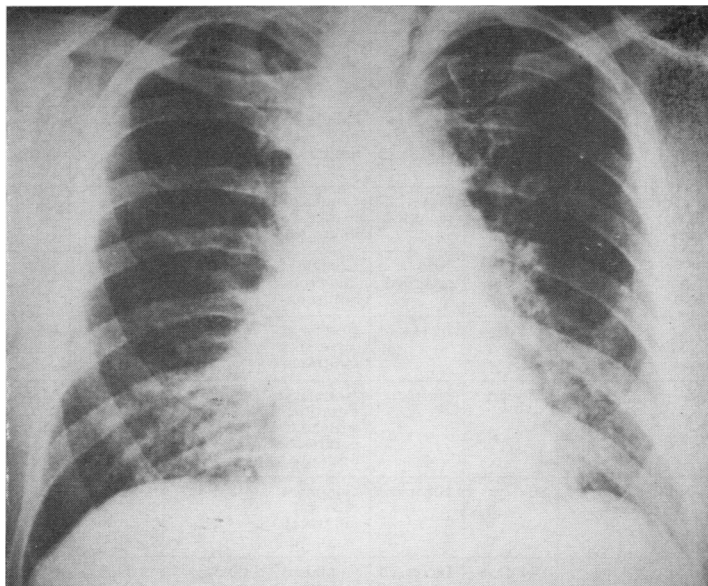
Chest radiograph demonstrating diffuse pulmonary mottling, most prominent in the lower and middle lobes.*
